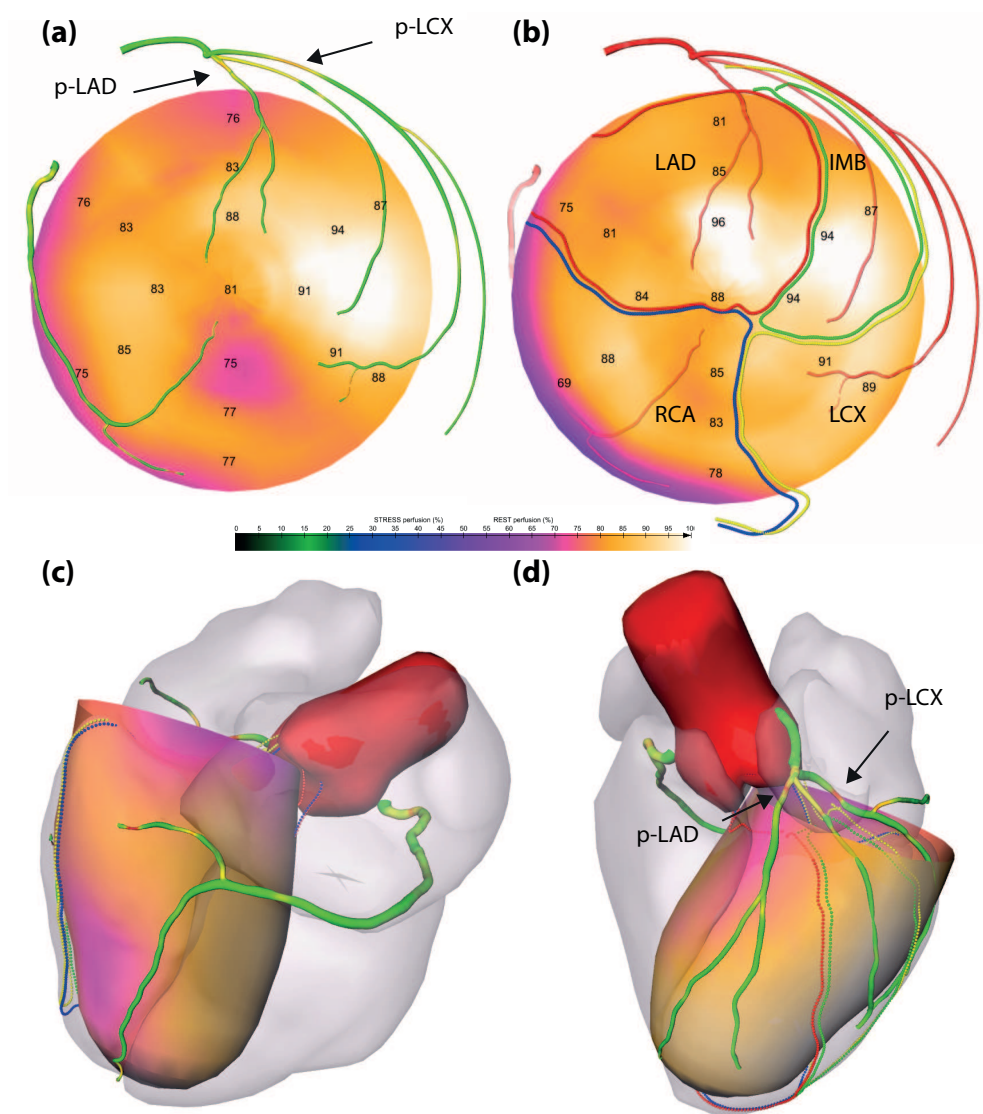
Example of patient 01 (61 y.o. male). (a) Stress polar map: the coronary vessel tree is color-coded with the automatically estimated degree of stenosis. (b) Rest polar map: the coronary arteries are coded with the distance to the epicardium: the more transparent the artery, the further it is from the epicardium. Patient-specific perfusion territories are also projected: LAD in red, LCX in yellow, MO in green and RCA in blue. (c)(d) 3D model of the heart and coronary artery tree extracted from CTA fused with 3D stress polar map.
